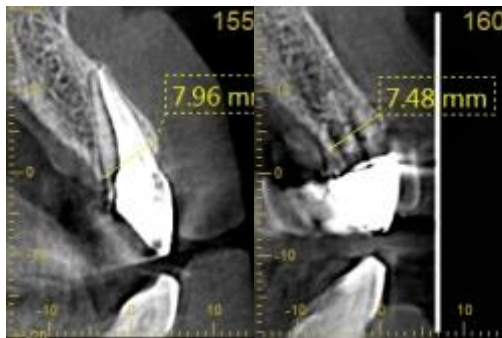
X-ray slice of tooth 21 after 9 months showing stable dimensions of alloplastic augmentate
